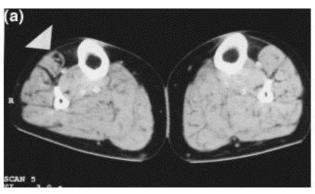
CT scan of the leg muscles of a 64-year-old female patient with 8-10 years of symptoms and inability to walk on her heels. Selective fatty degeneration of the TA muscles is shown on both sides with an early degeneration of the right extensor hallucis longus muscle (arrowhead).
